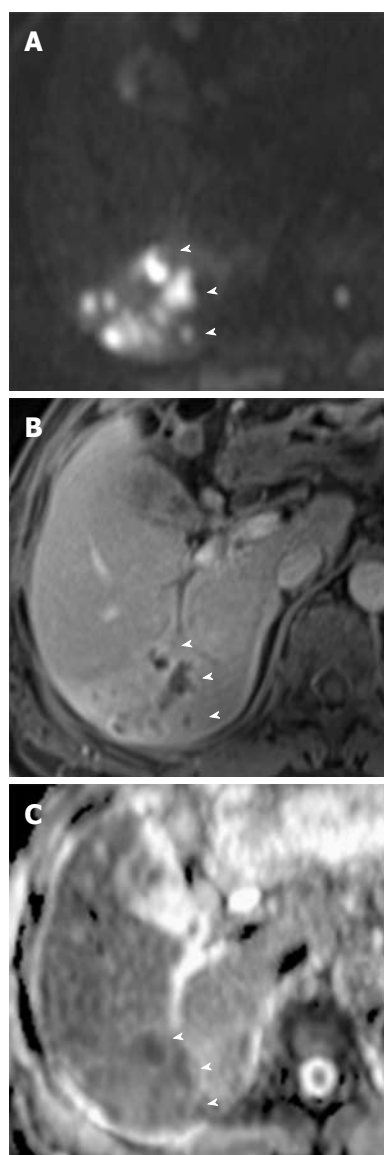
Liver abscesses complicating acute cholangitis in a 79-year-old man. A: DWI at $b = 1000 \text{ s/mm}^2$ shows multiple liver abscesses with high signal intensity (arrowheads); B: Multiple abscesses with peripheral rim enhancement (arrowheads) are less conspicuous on contrast-enhanced fat-saturated T1-weighted images (B) than on DWI (A); C: On an ADC map, multiple abscesses appear as low signal intensity (arrowheads) due to restriction of diffusion. DWI: Diffusion-weighted magnetic resonance imaging; ADC: Apparent diffusion coefficient.
